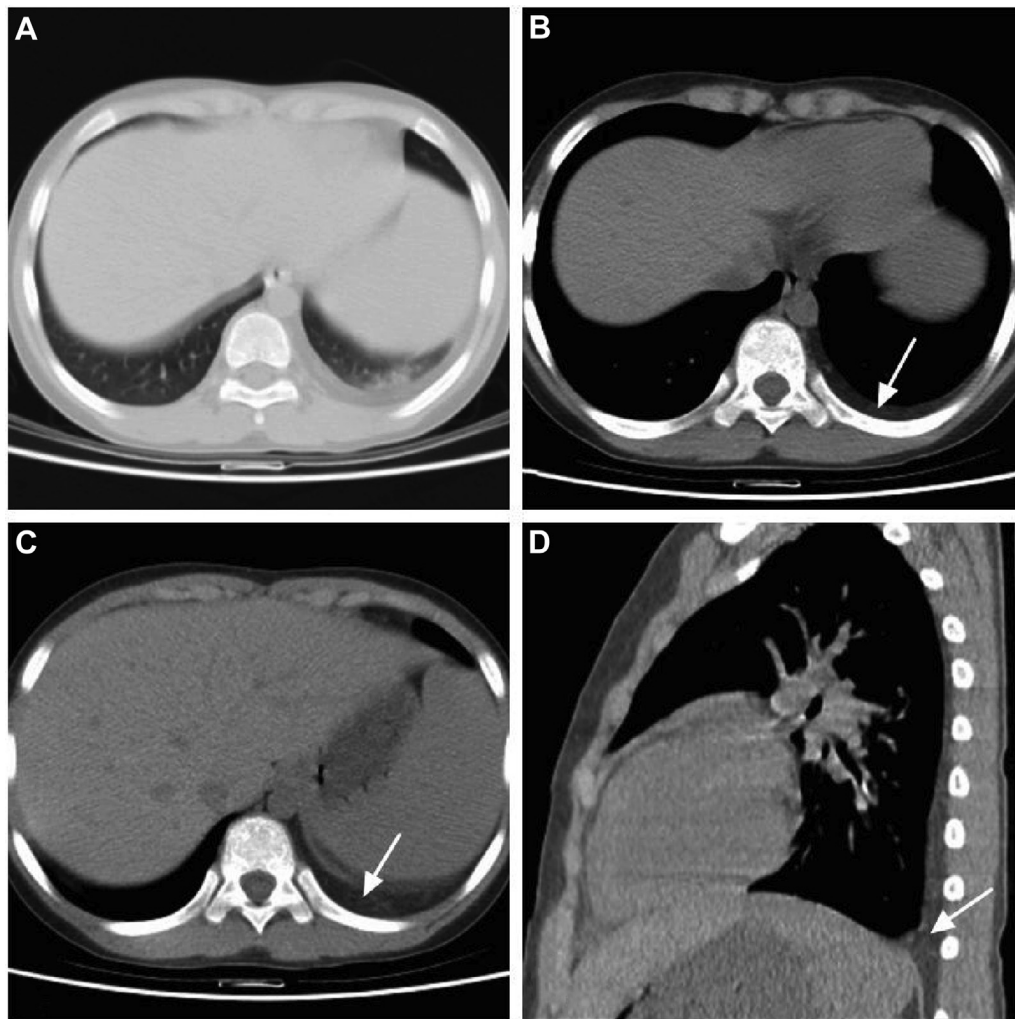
(A) Patchy density of the left lower lobe diagnosed as focal infection. (B–D) The soft tissue (white arrows) posterior to the diaphragm with average computed tomography (CT) value between -61 Hu and -91 Hu, consistent with fat tissue, diagnosed as local fat infiltration of the left thoracic cavity.
